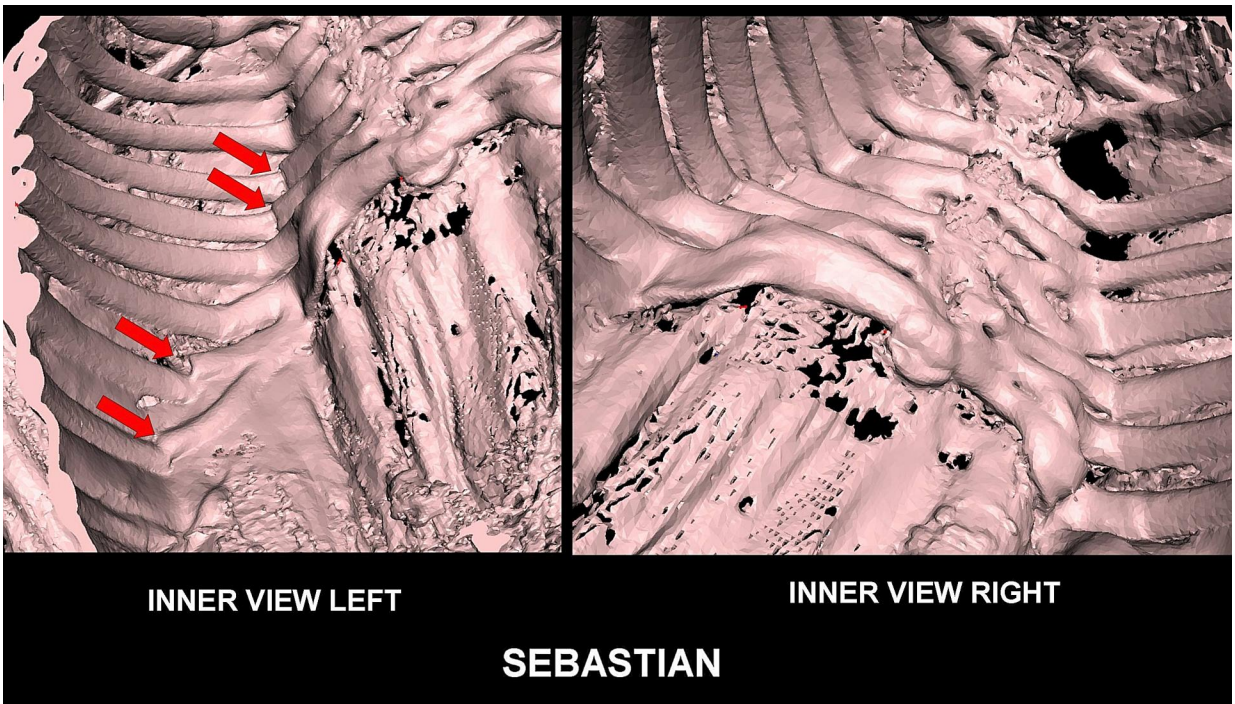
3D CT showing inner aspect of thoracic cage. Subluxations were seen in left 6th, 7th, 10th and 11th costochondral junctions (*red arrows*).
